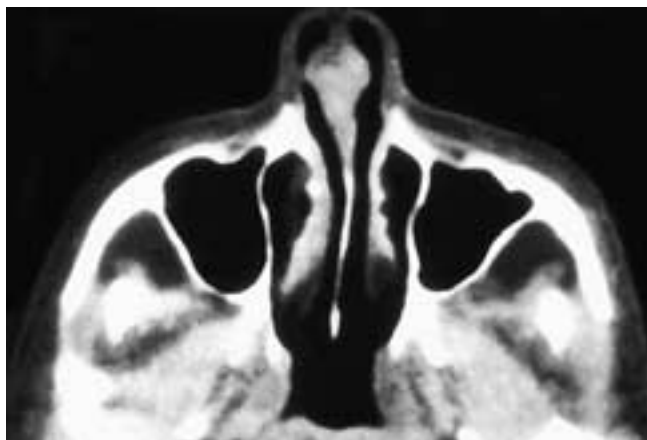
Axial CT scan shows localized soft-tissue thickening of the anterior nasal septum. This appearance suggests either granulomatous disease or a cartilaginous tumor. This patient had Wegener's granulomatosis.
